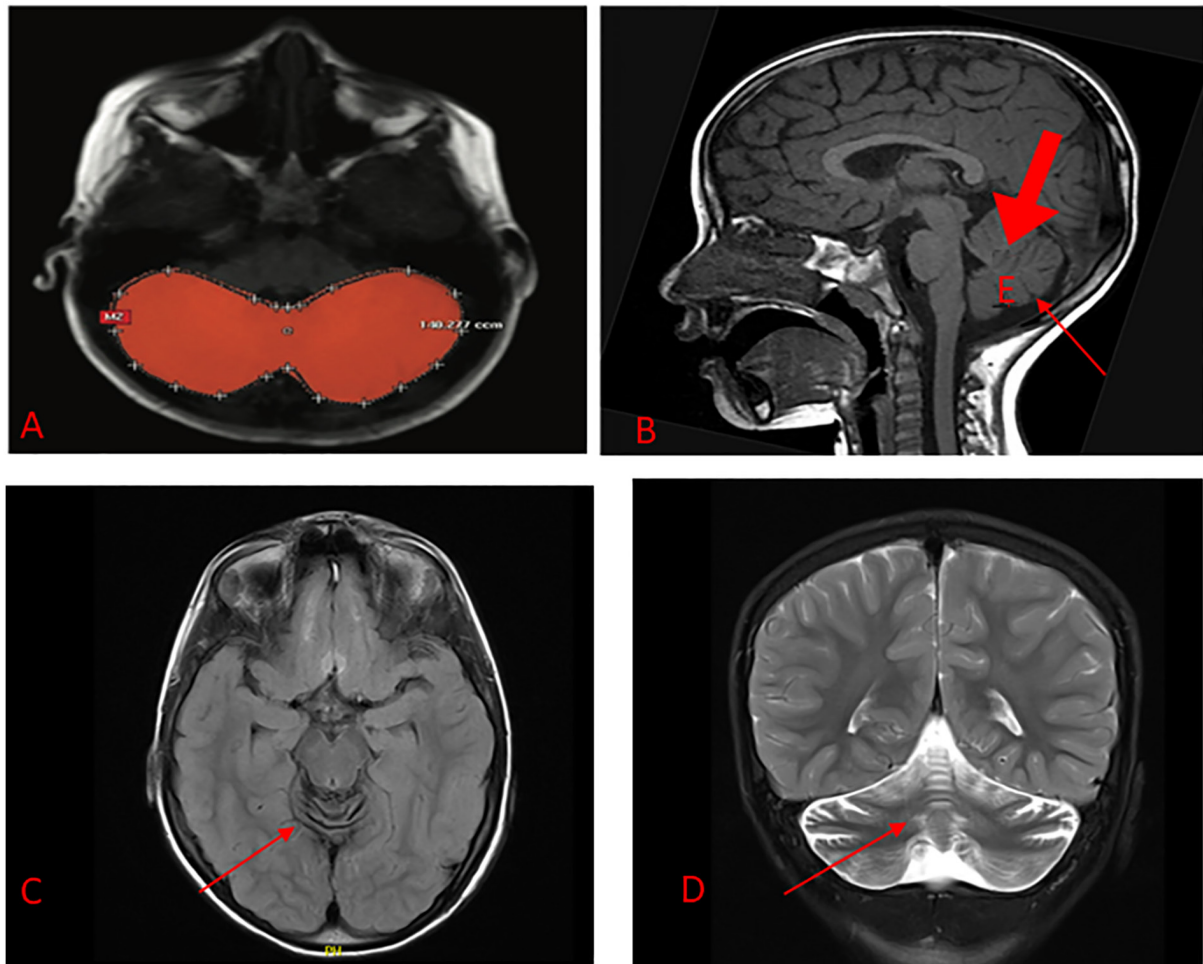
MRI images of the patient. (A) Axial MRI displaying cerebellar volume measurement; the red zone indicates the brain area. (B) Normal brain MRI of a sagittal view demonstrates normal vermis structures. (C) axial view and (D) coronal view demonstrate diffuse cerebellar atrophy and vermian hypoplasia. Primary fissures (thick arrow) and pre-pyramidal fissures (thin arrow) are visible in the fastigium. (E) fastigium.
